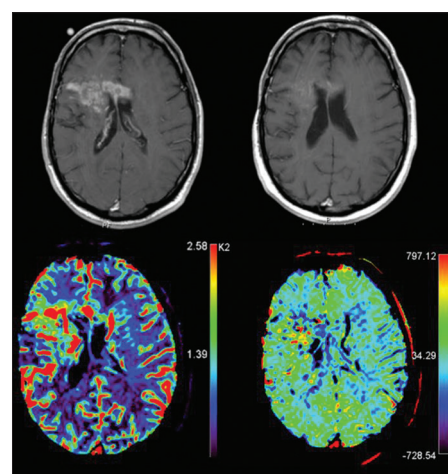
Dynamic susceptibility contrast perfusion imaging. Pseudoresponse: Recurrent GBM under Bevacizumab. Despite radiographic response on the contrast-enhanced T1w image (upper row), there is a persistence of elevated relative cerebral blood volume and increased leakage indicating pseudoprogression
